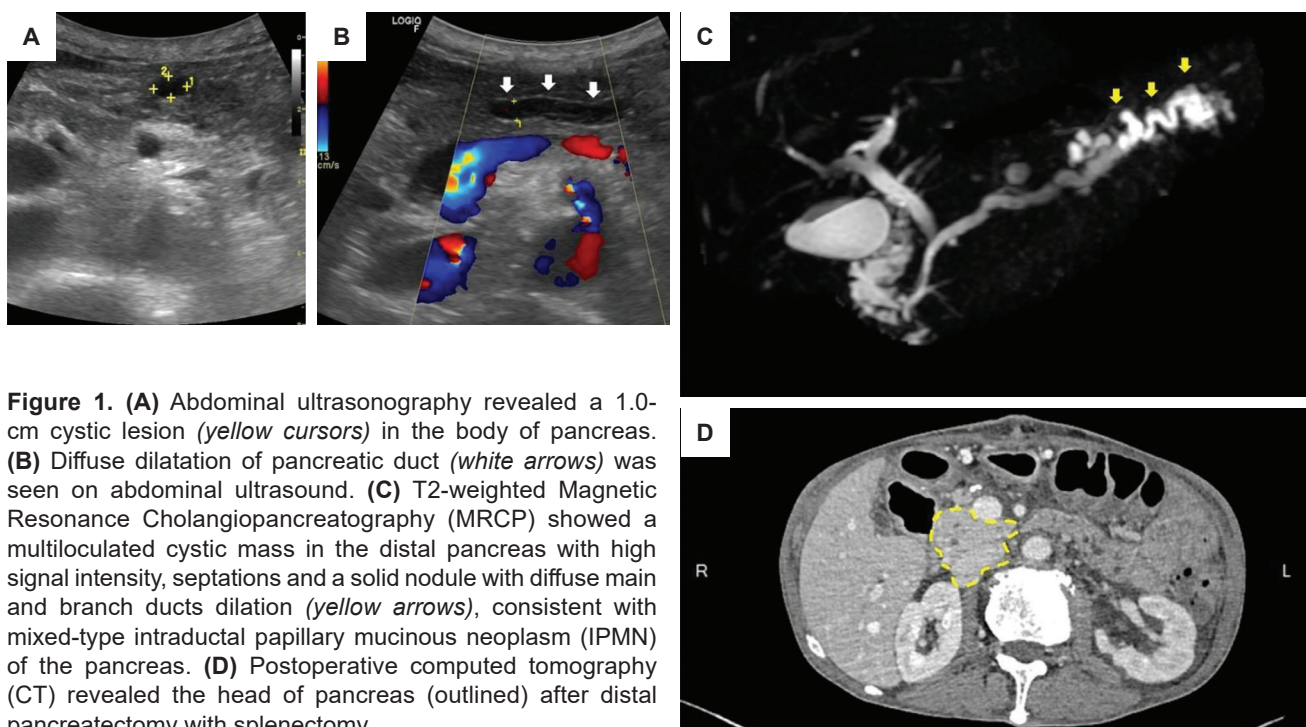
(A) Abdominal ultrasonography revealed a 1.0-cm cystic lesion (yellow cursors) in the body of pancreas. (B) Diffuse dilatation of pancreatic duct (white arrows) was seen on abdominal ultrasound. (C) T2-weighted Magnetic Resonance Cholangiopancreatography (MRCP) showed a multiloculated cystic mass in the distal pancreas with high signal intensity, septations and a solid nodule with diffuse main and branch ducts dilation (yellow arrows), consistent with mixed-type intraductal papillary mucinous neoplasm (IPMN) of the pancreas. (D) Postoperative computed tomography (CT) revealed the head of pancreas (outlined) after distal pancreatectomy with splenectomy.
